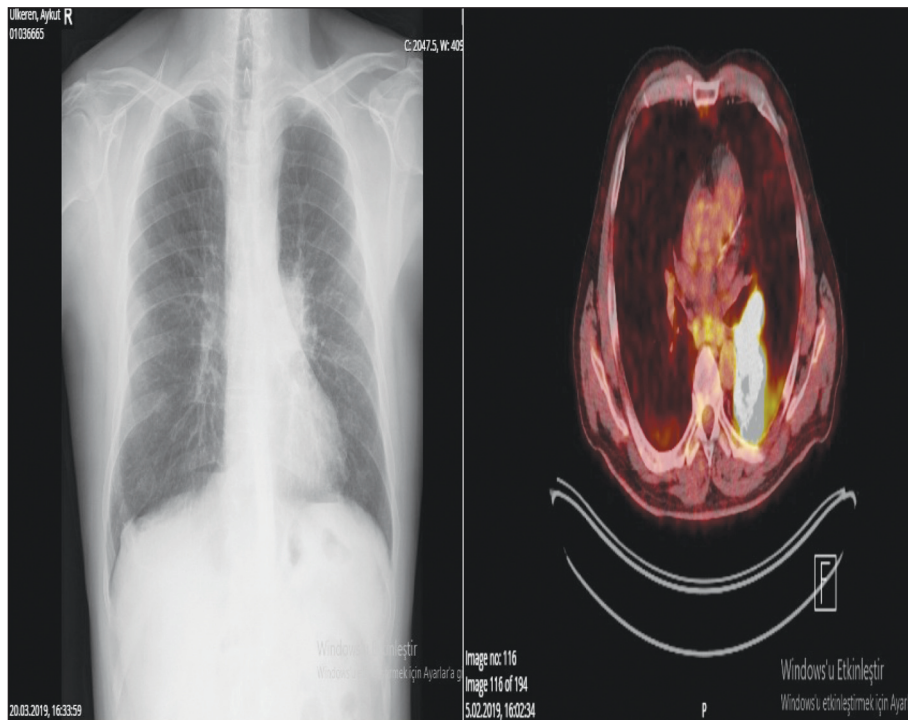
Mass in the left lung on radiograph and positron emission tomography with computed tomography at the time of diagnosis.
